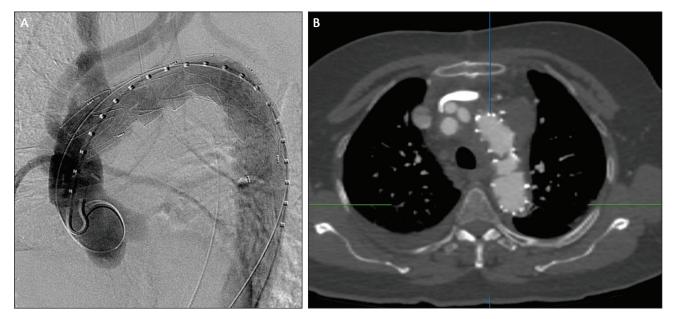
After stent-graft deployment. Complete angiogram (A) and CT scan (B) showing exclusion of the aneurysm by the stent-graft.
